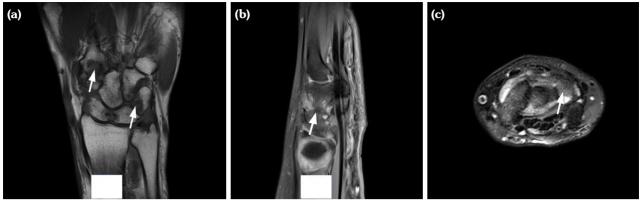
Magnetic resonance imaging of SPRA bone erosion. A 54-year-old woman diagnosed with SPRA; MRI images of the right wrist. (a) (coronal plane), (b) (sagittal plane), (c) (cross section): nodules on the eroded carpal tunnel bone with low T1W1 signal (indicated by the arrow); Abnormal bone signals were also seen at the proximal end of the carpal and metacarpal bones, with narrowed joint spaces and blurred edges (indicated by the arrow). SPRA: Seropositive rheumatoid arthritis; MRI: Magnetic resonance imaging.
